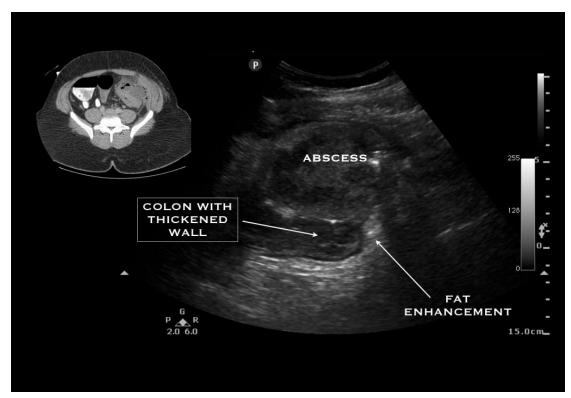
A bedside ultrasound used to diagnose an intraabdominal abscess in a patient with perforated diverticulitis.
